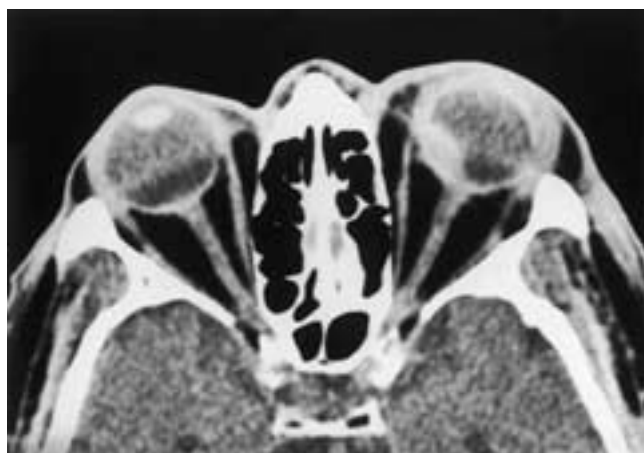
Ocular trauma and choroidal hematoma. Axial CT scan shows a hyperdense left choroidal hematoma. This can be confused with a choroidal melanoma.
